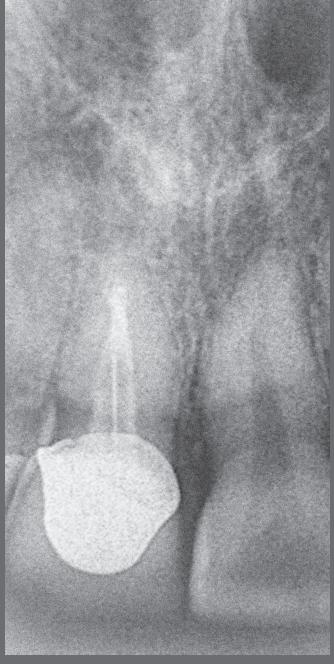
Immediate X-ray after anatomic FGP cementing.
